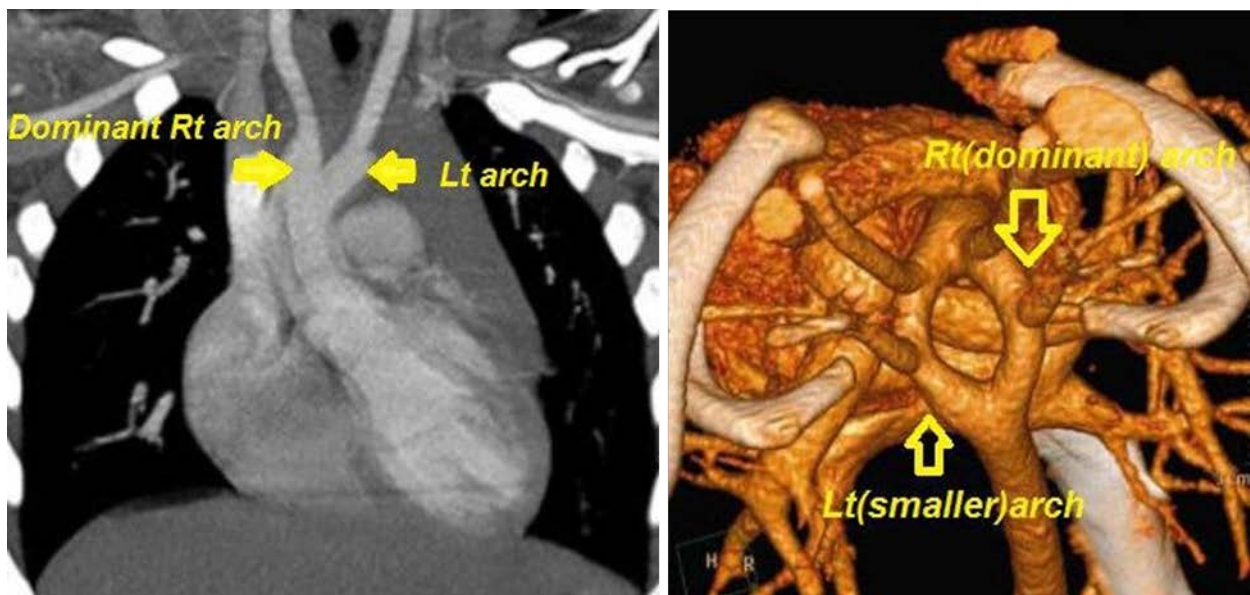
Left) CT angiography (frontal view) shows double aortic arch, right arch dominance, and smaller left arch. Right) Reconstructive CT angiography shows Right and left side aortic arch
